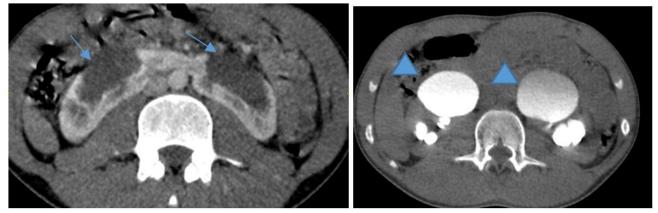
Axial and coronal computed tomography (CT): showing the two kidneys with pelvic dilatation(arrows) contrasting in late times (arrowhead) and normal caliber ureter suggesting stenosis of the ureteropelvic junction.
